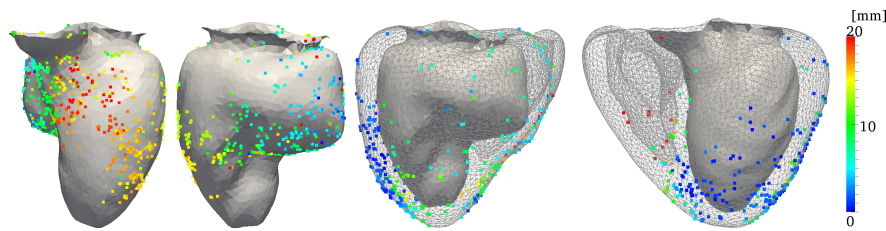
The computational mesh extracted from the MR images and the observation points. On the left two views of the endocardial surface is shown with the observation points plotted on top. On the right two views of the epicardial surface is also drawn (as a wire mesh). The observation points on the two surfaces are depicted in the images where the colors correspond to the *distance each point was projected to the mesh surface*.
